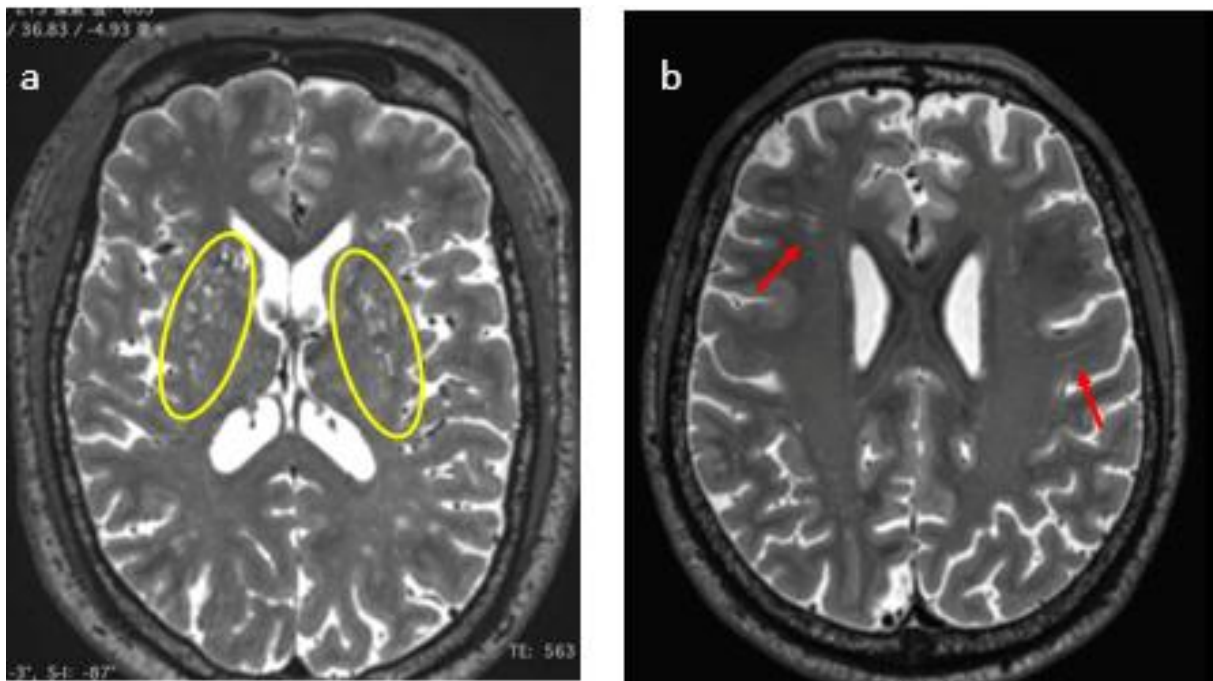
A case of MRI-defined ePVS. Figure 2-5(a) presents bilateral dotted, round, hyperintensities in the basal ganglia region, Grade 2>20 ePVS. Figure 2-5(b) presents bilateral linear hyperintensities in the centrum semiovale region, ePVS Grade 1<10 ePVS.
